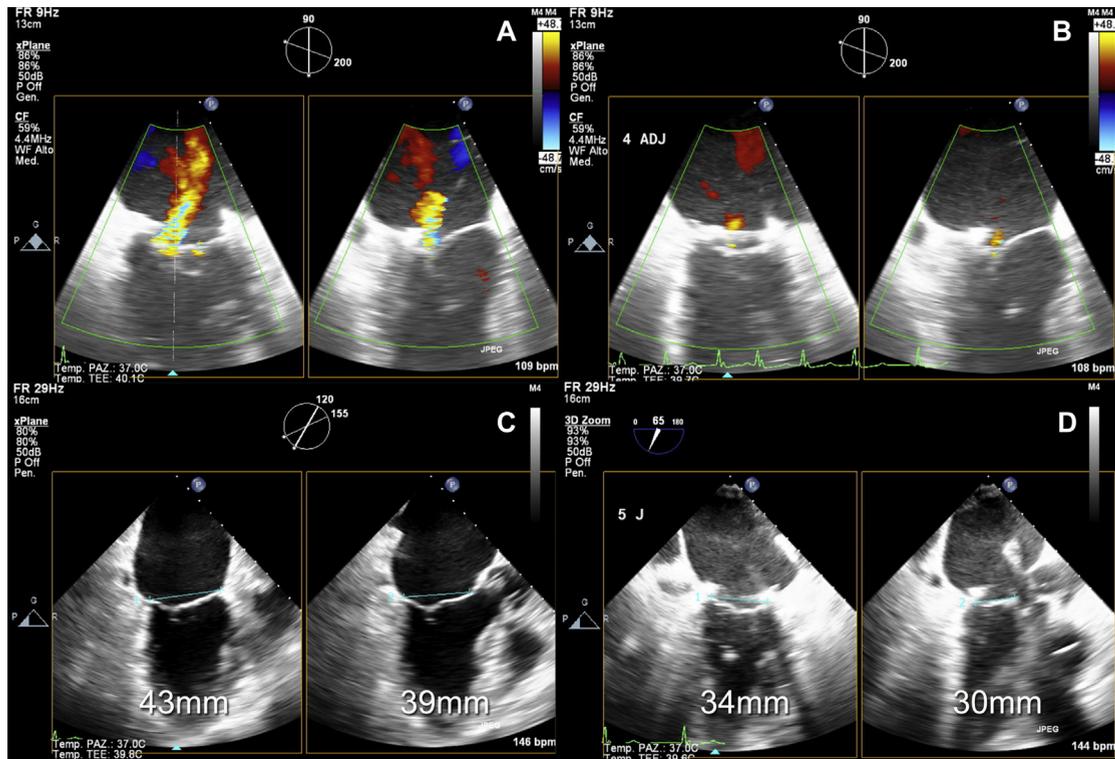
Baseline and Post-Adjustment Echocardiography
